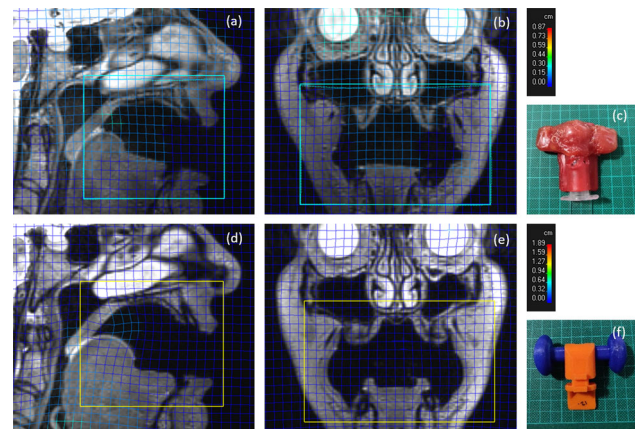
Sagittal and coronal MRI slices showing deformation matrices obtained from registering repeat images with the same stent, for wax stent (top row) and modular 3D printed stent (bottom row)
